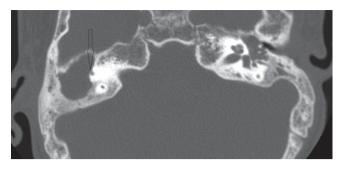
An axial CT image of the right ear with a cholesteatoma. Extensive erosion with typical scalloping of bone is seen in the right mastoid cavity in which there is also a fistula to the anterior limb of the superior semicircular canal (ampullated end marked with a *black arrow*). (Copyright held by Dennis S. Poe, MD, PhD, Boston Children's Hospital)
